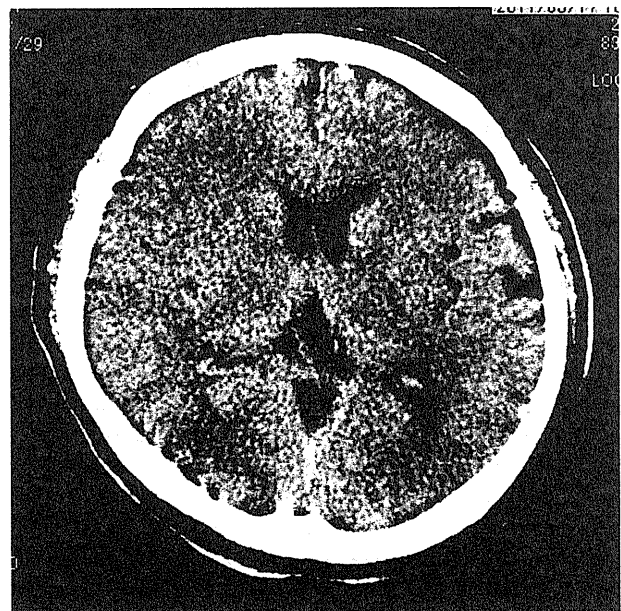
Computed tomography scan after hyperbaric oxygen therapy revealing diffuse brain edema.
